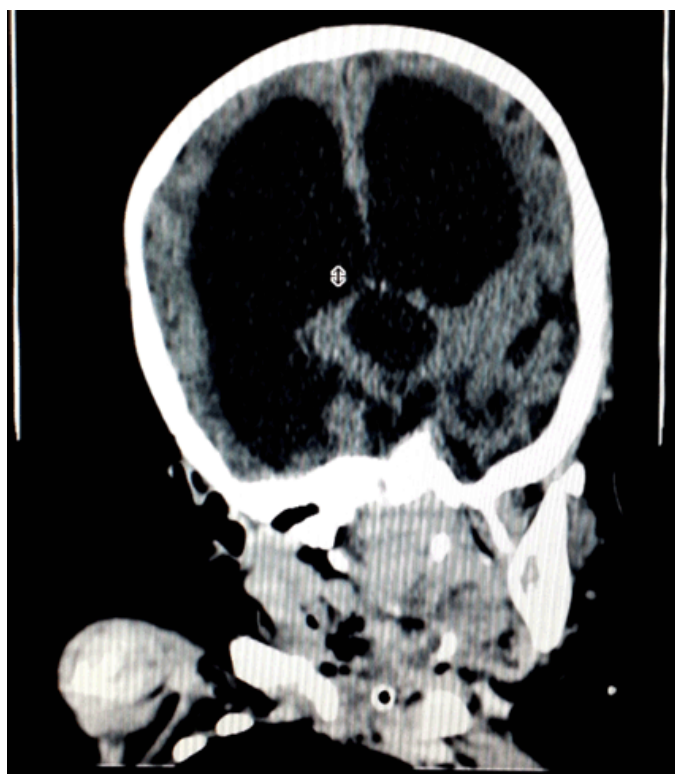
A coronal section of the computed tomography scan of the head of the patient showing another view of the hydrocephalic brain.
